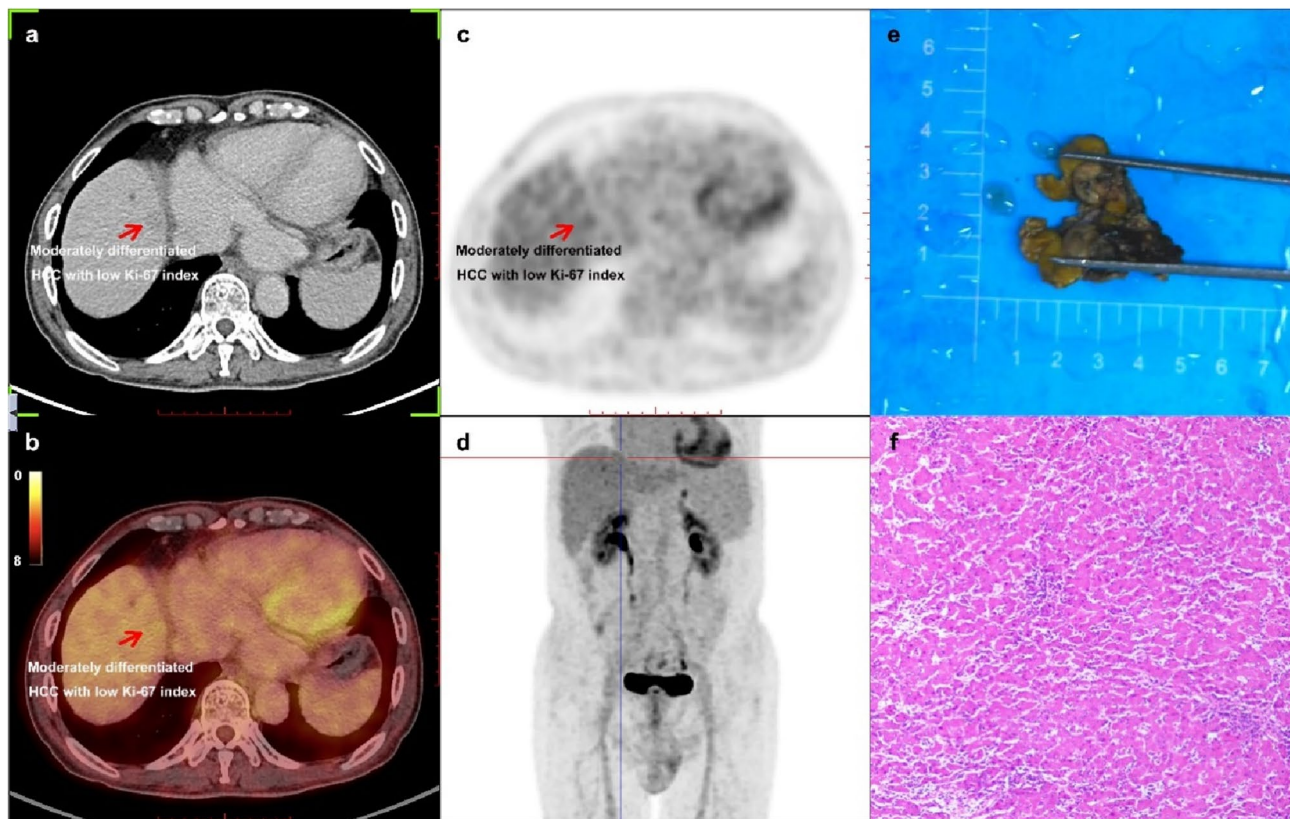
Example for a 70-year-old newly diagnosed HCC male man detected by ^{18}F -FDG PET/CT inspection. a CT (computed tomography) image of the lesion located in liver S8 which was a hypodense nodule on delayed phase. b PET/CT fusion image of the lesion. c PET image of the lesion, and the SUV_{max} (maximum standardized uptake value) of this lesion was 3.10, the lesion-to-liver SUV_{max} ratio
